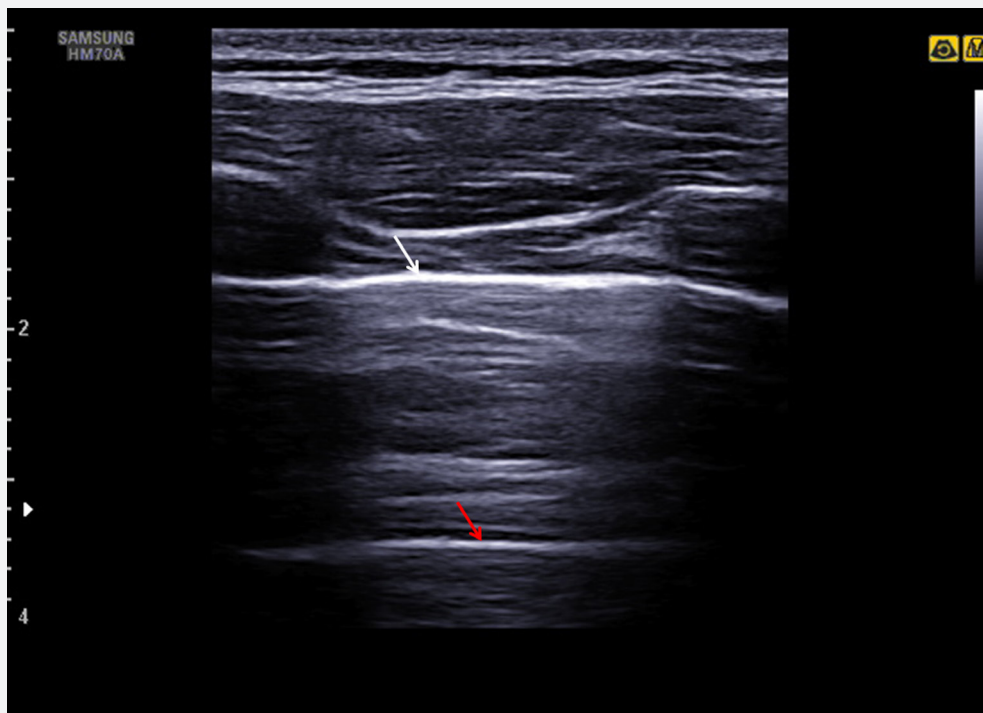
Ultrasound image using the Samsung HM70A.
